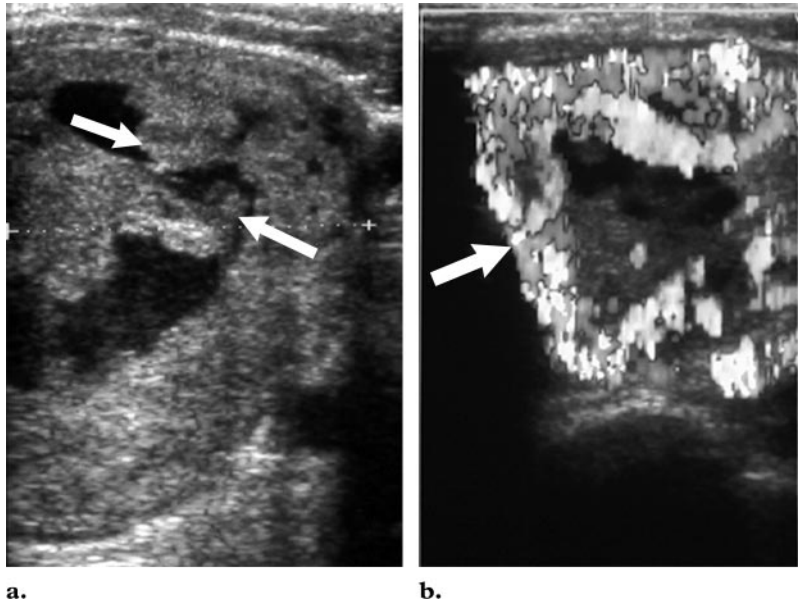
Hürthle cell (follicular) carcinoma in a 60-year-old woman. (a) Transverse sonogram of the left lobe of the thyroid shows a partially cystic tumor with solid internal projections (arrows) and thick walls. (b) Color Doppler sonogram (shown in black and white) depicts increased vascularity in the solid parts of the tumor (arrow).
